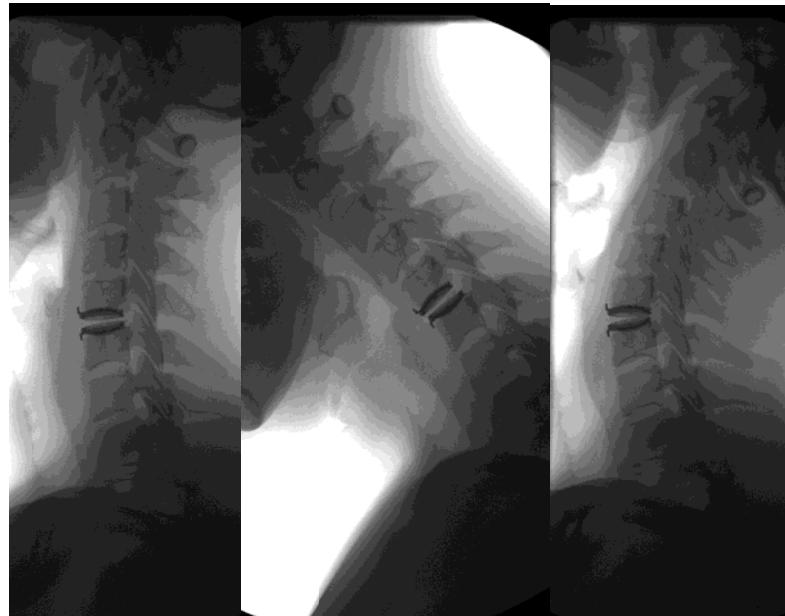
X-ray radiography with functional samples after the functional disk installation of the cervical spine
